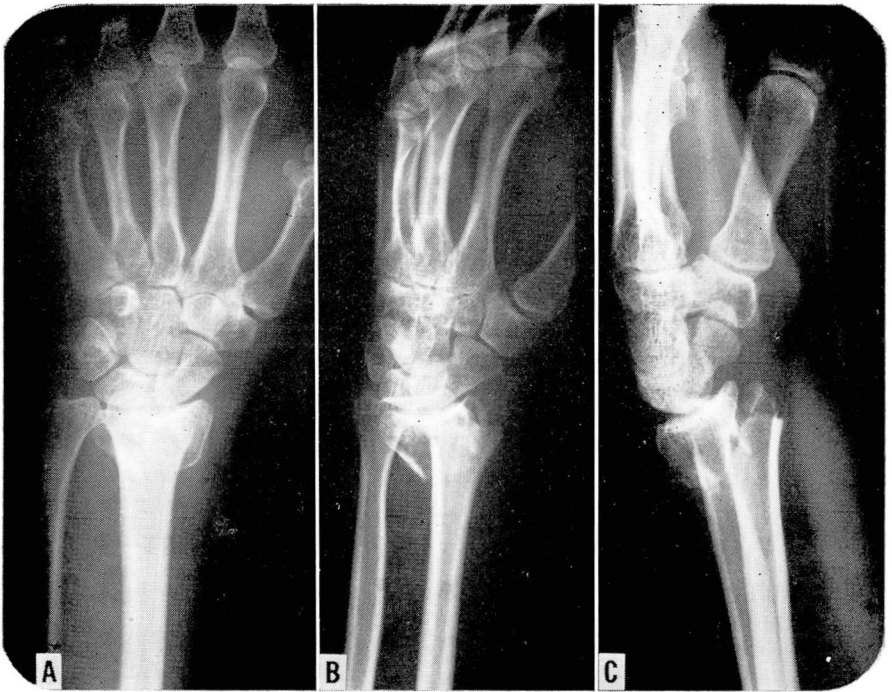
Posteroanterior (A), oblique (B), and lateral (C) roentgenograms showing comminuted fracture of distal end of radius and ulna in a 44-year-old woman.
